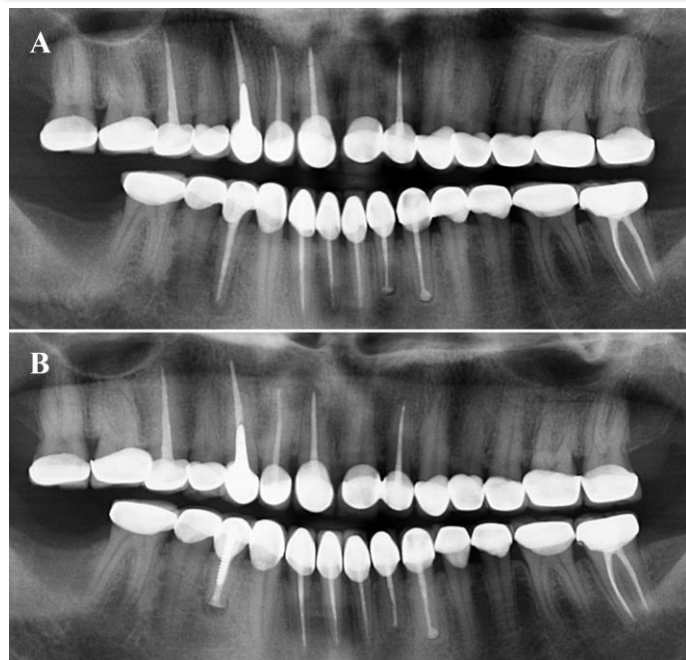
6-year (A) and 10-year (B) follow-up panoramic radiography.
